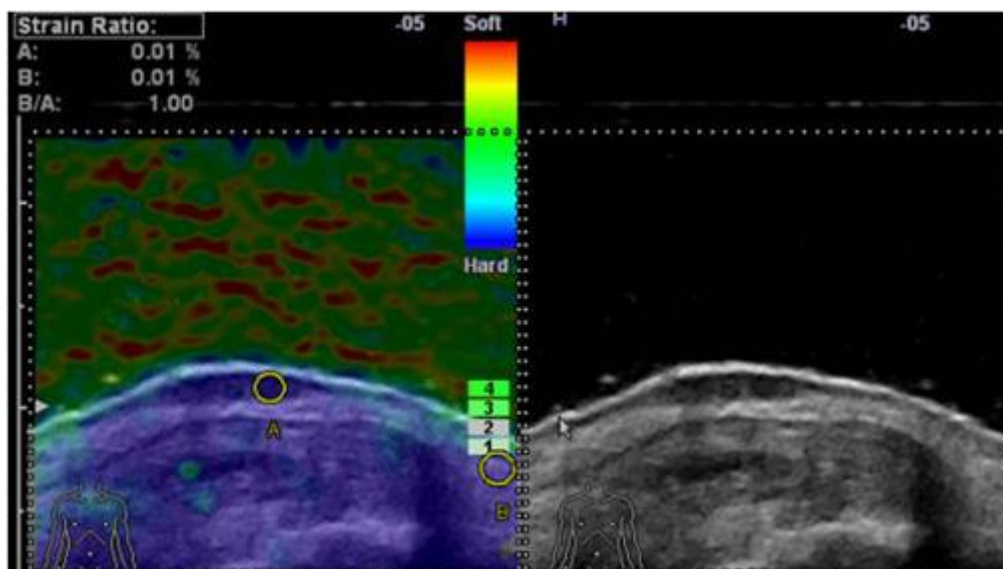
An elastogram (left) and ultrasound image (right) showing malignant melanoma of the skin (Lassau et al., 2002).
